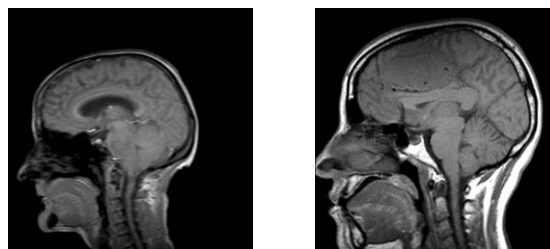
Monomodal Images (MRI).
